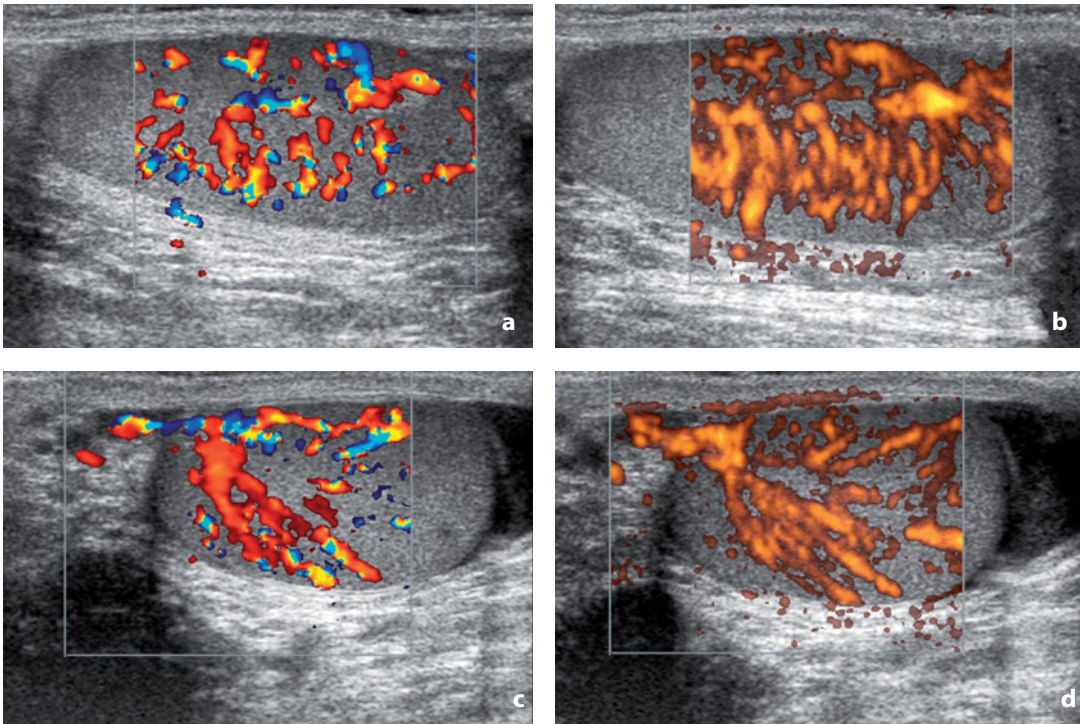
Color and power Doppler. Vasculature of the normal testicle. a,b Longitudinal scans. c,d Transverse scans. The images afford a comparison of color Doppler (a,c) and power Doppler (b,d)
